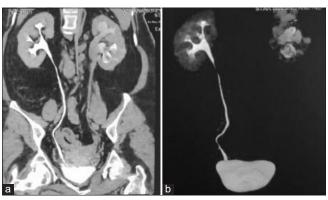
(a) Computed tomography intravenous urography – thickened left proximal ureter causing obstructive changes suggestive of stricture. (b) Computed tomography intravenous urography – hypodense debris in the lower pole of the left kidney without drainage of contrast
